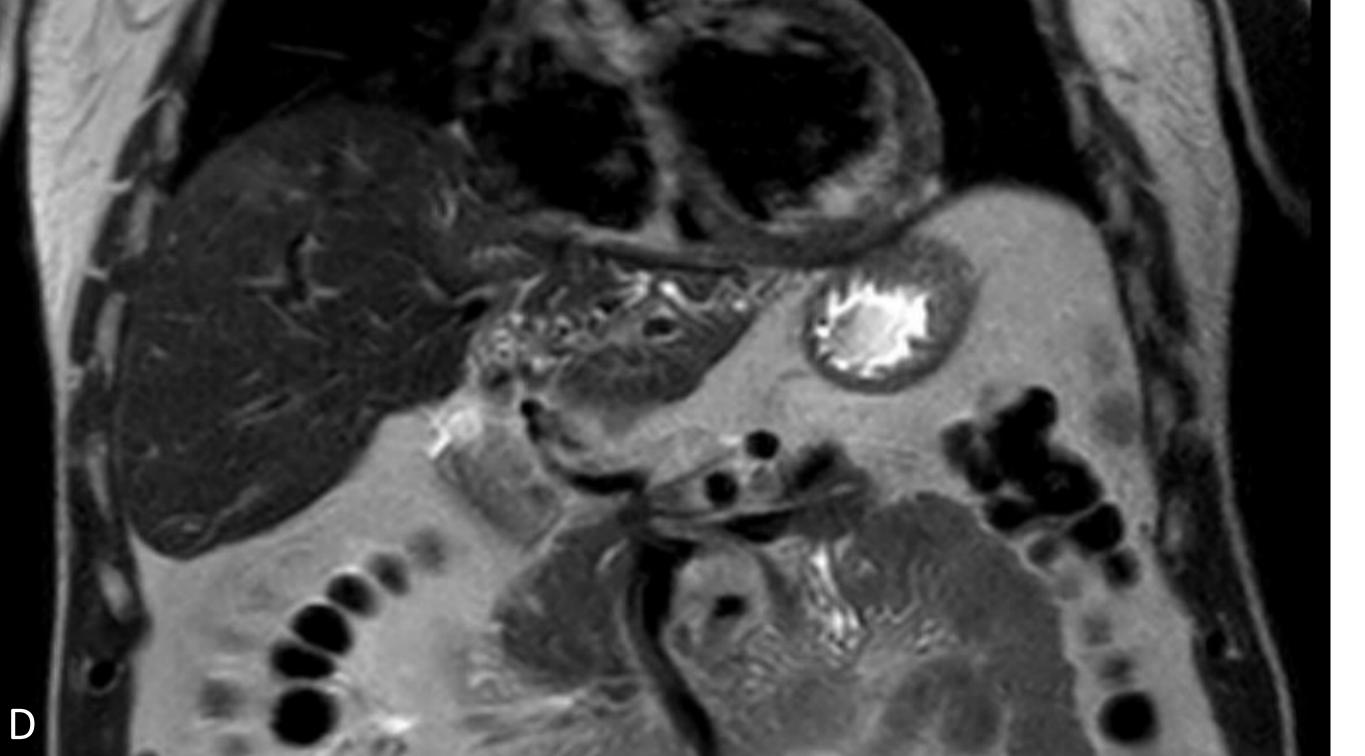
Magnetic resonance imaging with atrophic left liver lobe in diseased segments
